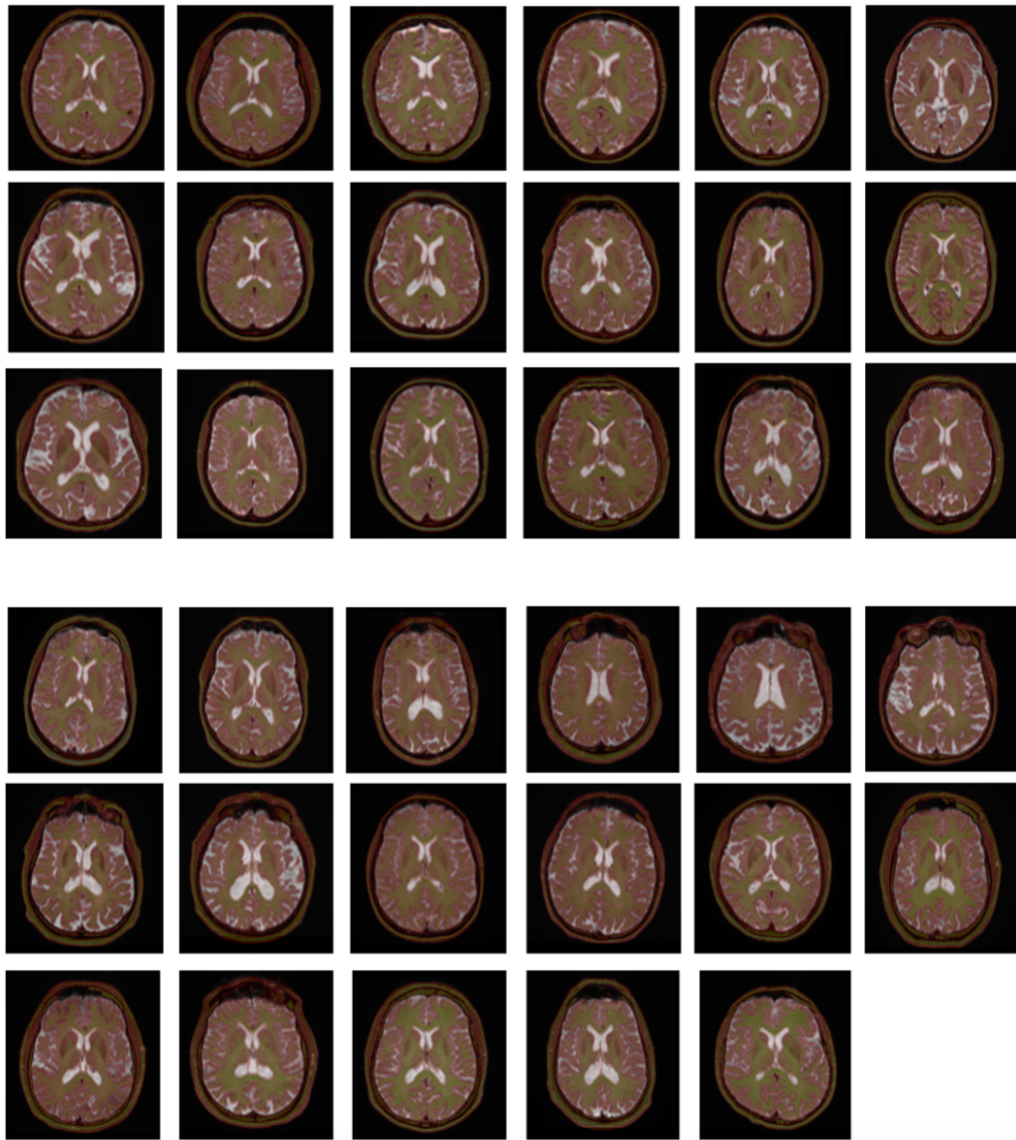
Overlay of the registered T1-weighted volume (in red) over the mean b0 volume (in gray scale) for all subjects (representative slices).
